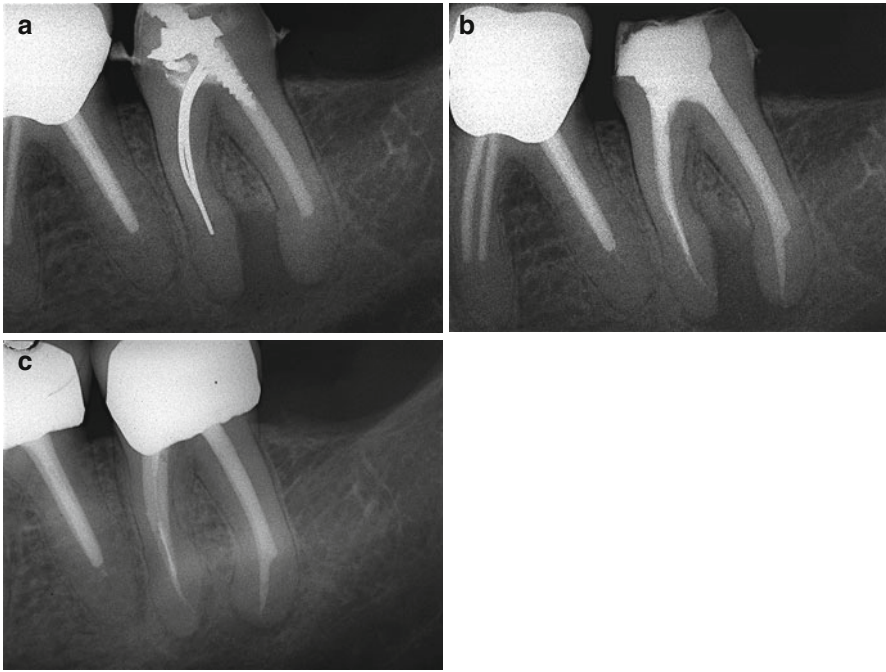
(a) Left mandibular second molar with insufficient endodontic treatment. The distal canal has been substantially enlarged, and a wide ledge is present. (b) Postoperative radiograph showing retreatment. Note the wide ledge present in the distal root. (c) Follow-up after 1 year
